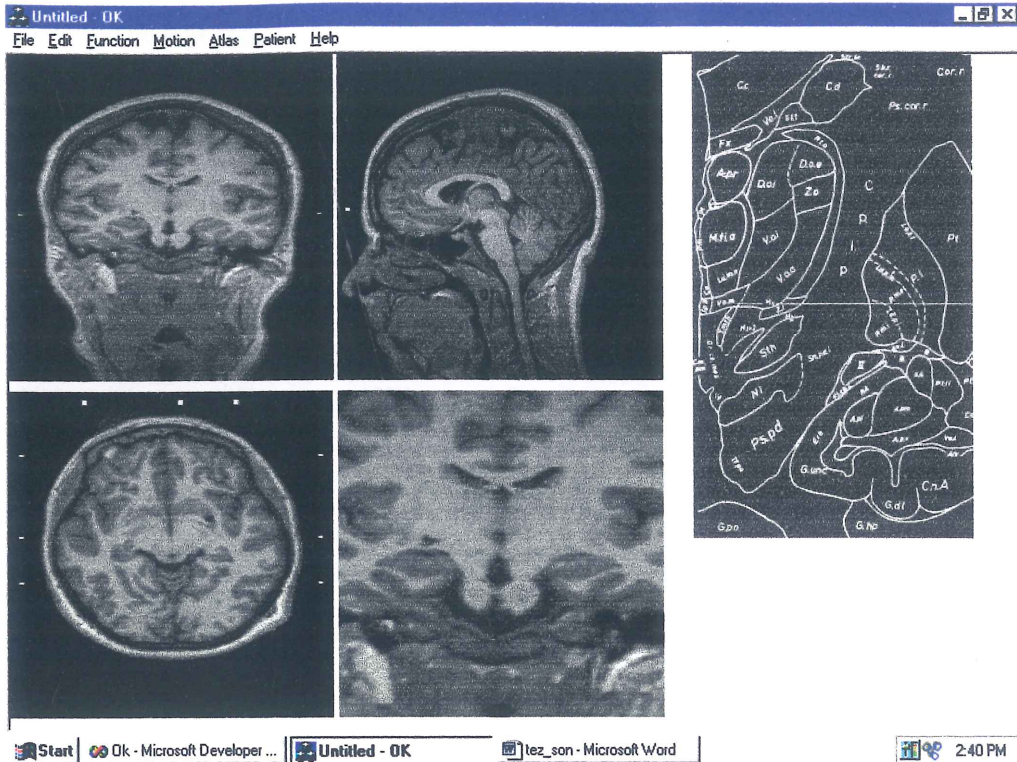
Case where sagittal CT view, zoom view and atlas view are the same.
